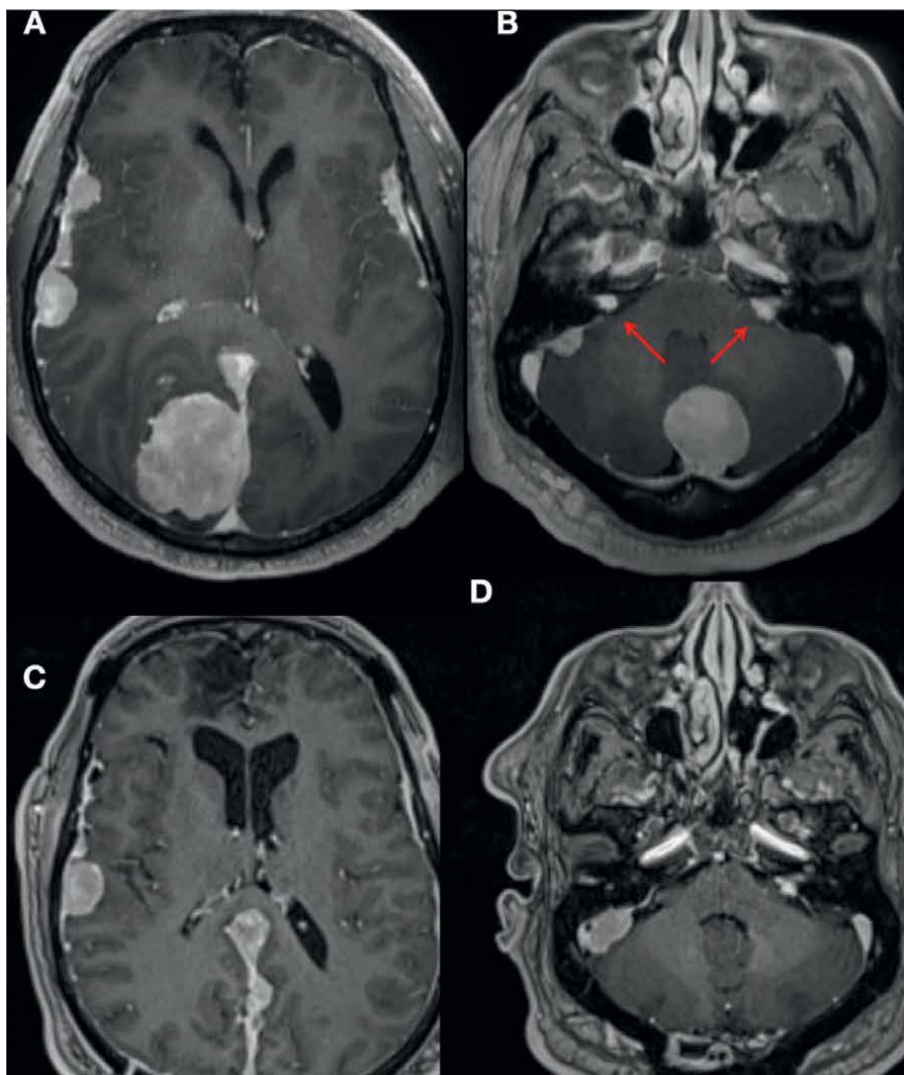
Post-contrast T1-weighted MRI images in the axial orientation. Panel A shows a large meningeioma that is attached to the posterior falx. Panel B shows a large meningeioma attached to the dura of the posterior fossa. The arrows in this panel point to his vestibular schwannomas. Panels A and B show brain compression and narrowing of the right lateral ventricle in Panel A and 4th ventricle in Panel B. Panel C shows that the compression has been alleviated in the occipital area, and Panel D shows decompression in the posterior fossa. Panels A and B were performed before surgery. Panels C and D were performed 3 months after surgery.
